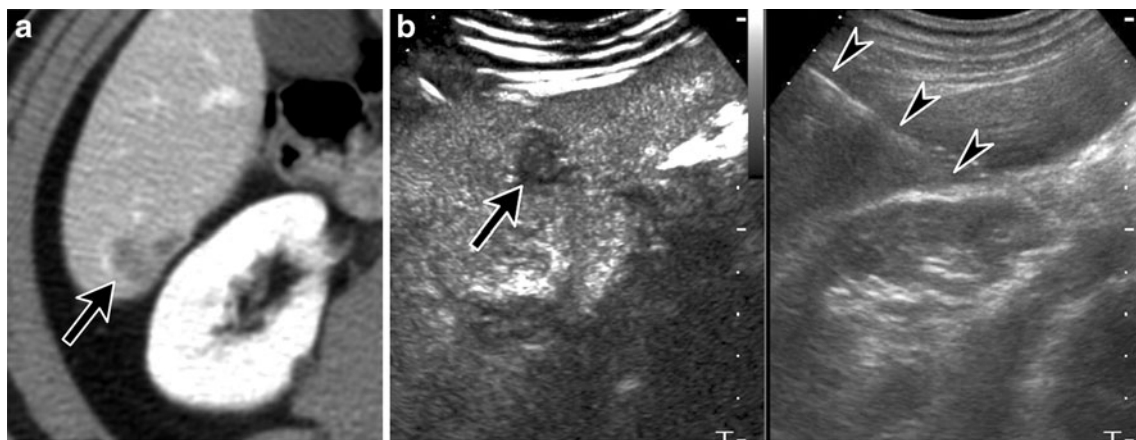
Hepatic metastasis from glottic cancer in a 57-year-old man. a Contrast-enhanced transverse CT shows a hypoattenuating focal lesion (*arrow*) at the segment 6. The target lesion was invisible on B-mode ultrasound (Supplemental Movie 2). b Split-screen display
